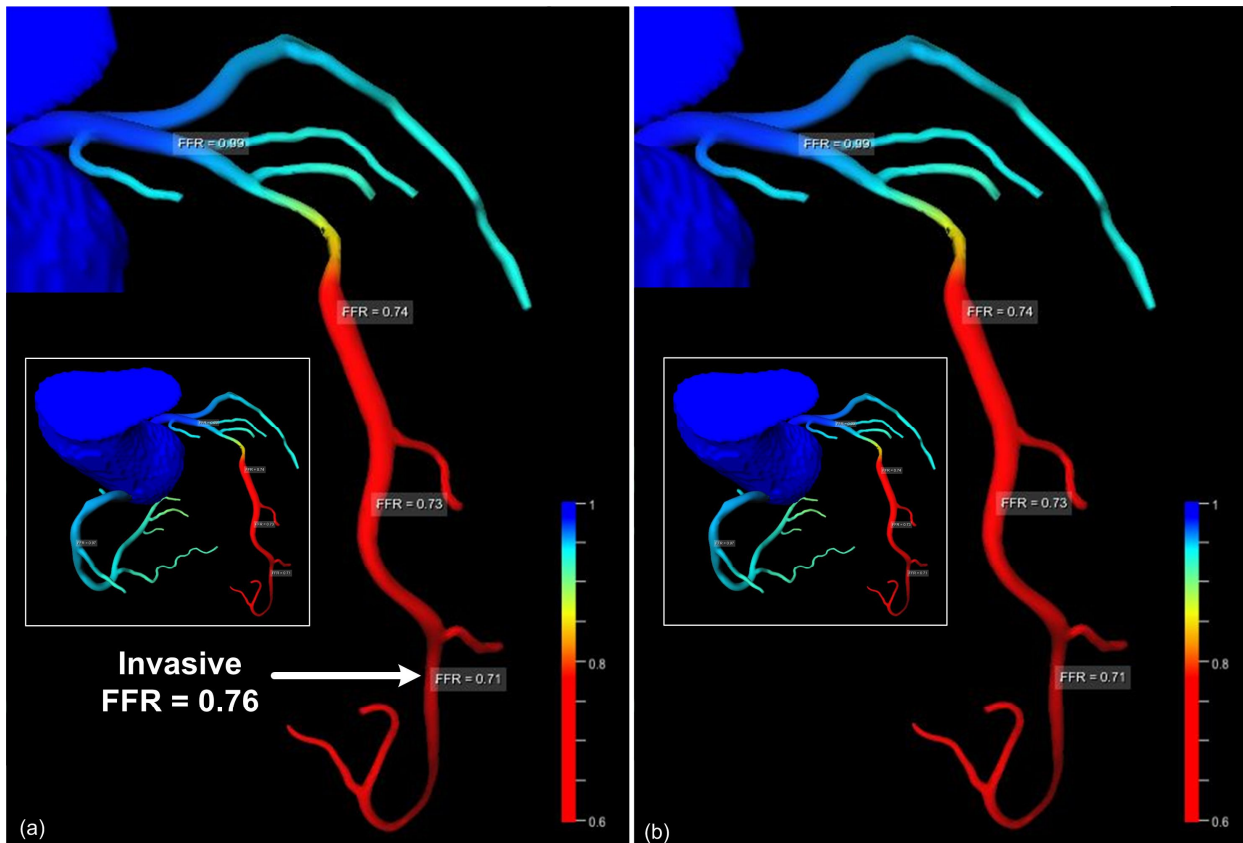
Case example of a coronary anatomical model reconstructed from CT data: (a) $cFFR_{CFD}$ map of the entire coronary tree, including a close-up view of the LAD, with invasive $FFR = 0.76$ and $cFFR_{CFD} = 0.71$ (b) $cFFR_{ML}$ map of the entire coronary tree, including a close-up view of the LAD, with $cFFR_{ML}$ equal to $cFFR_{CFD}$ at the invasive FFR measurement location.
